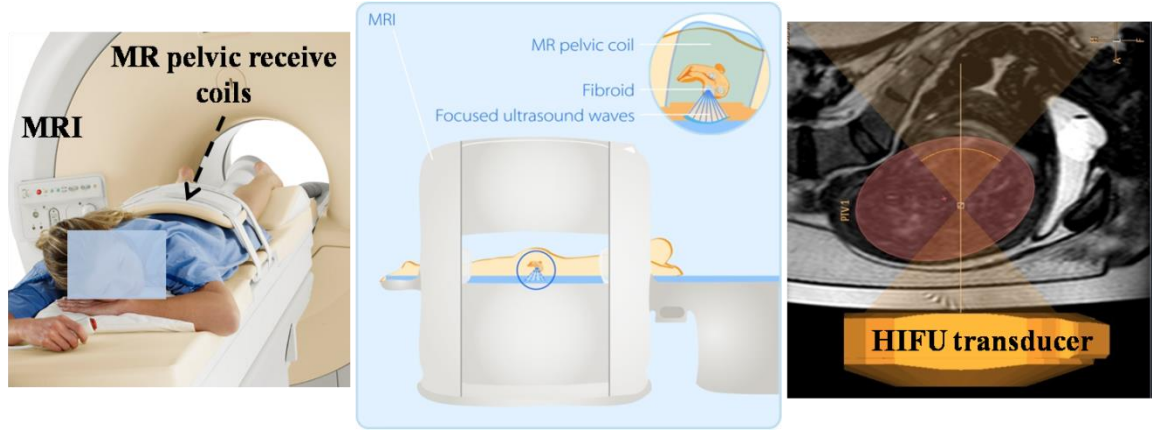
In-vivo* HIFU thermal ablation of uterine fibroid experiment setup. The patient lie down on the HIFU table in prone position with feet first entering MRI scanner (Left); Patient stayed still inside MRI scanner (Middle); Treatment planning based on anatomic MRI images (Right). Image courtesy of Phillips healthcare.
